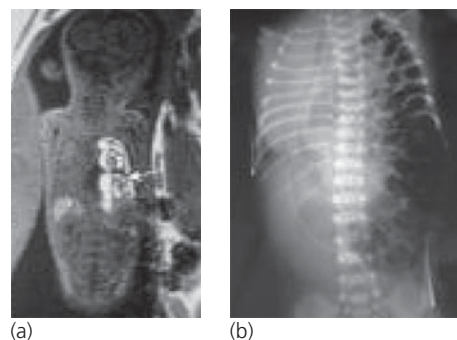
Congenital left diaphragmatic hernia shown on prenatal magnetic resonance imaging on the left and postnatal radiograph on the right.
